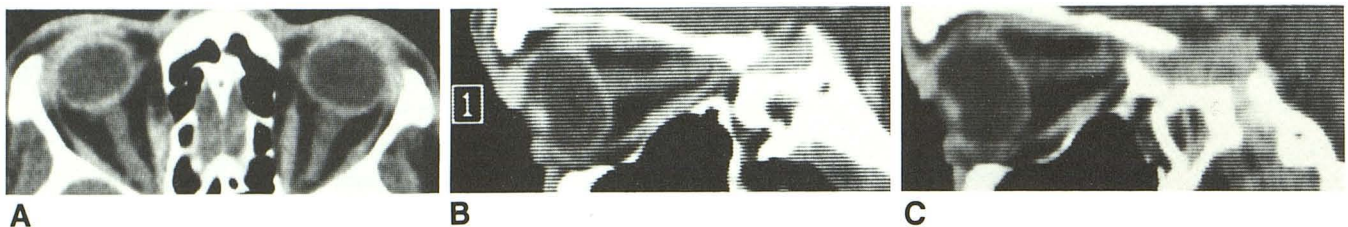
Case 2. Widening of nerve head at insertion. Axial (A) and sagittal (B, right eye; C, left eye) CT views of orbit in 47-year-old man with hyperopia and bilateral choroidal folds. Both globes show decreased
